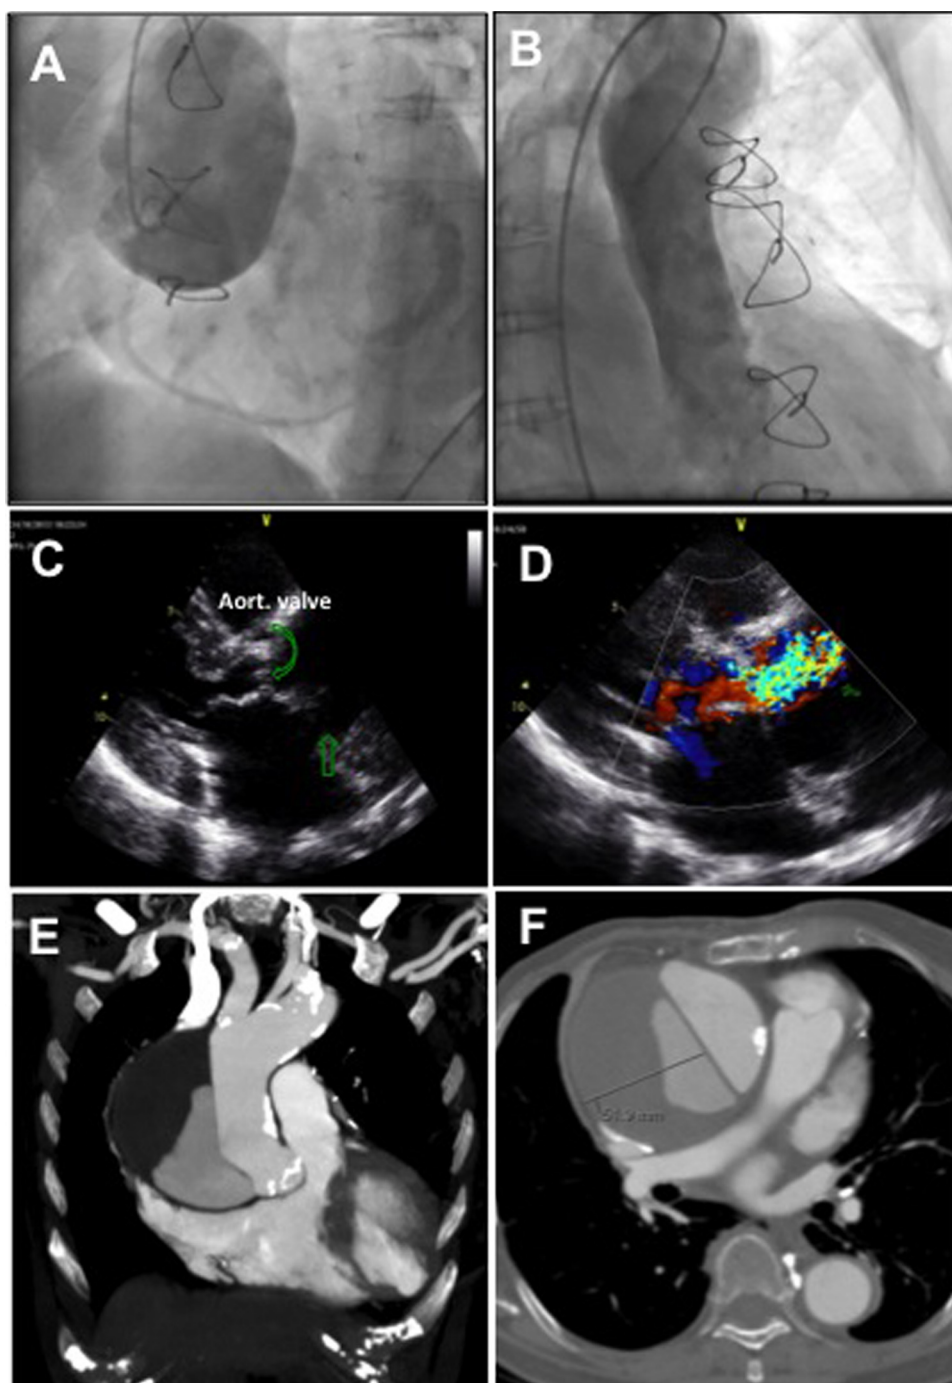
Chronic type A aortic dissection. (A) Angiographic visualization of the false lumen. (B) Angiographic visualization of the true lumen of proximal aorta. (C and D) Transthoracic echocardiogram in parasternal long axis view showing dilatation of the aortic root and a flap dividing the true and false lumen (arrow). (E and F) Thoracic angio-CT confirming type A aortic dissection with partial thrombosis of the false lumen.
